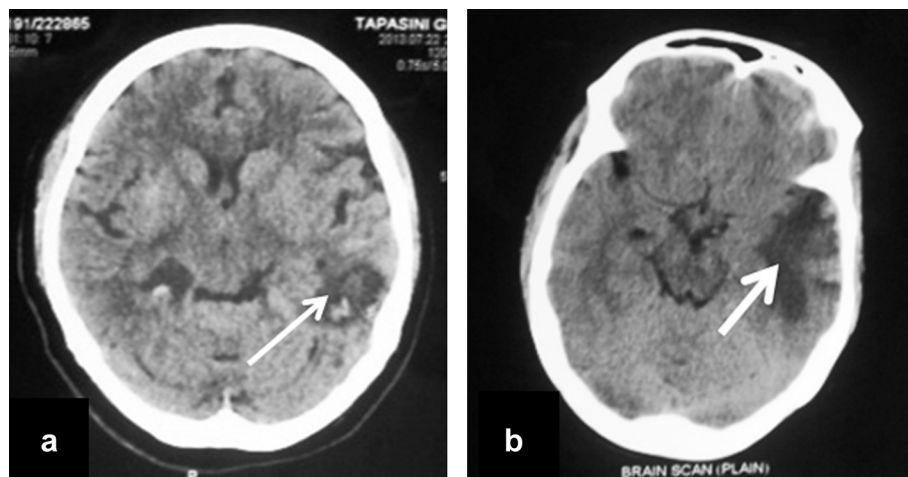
(a) CT scan of brain showing hypodense lesion in the Lt. Parietal region suggestive of hemorrhagic contusion. (b) Resolving contusion on repeat CT scan of brain 3 days after conservative management.
